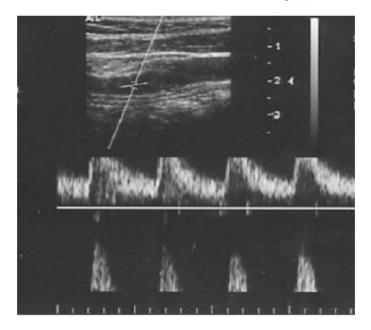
Aliasing on Doppler spectra. Due to the lower pulse repetition frequency (or low scale), the machine cannot measure the peak velocities. The top of the spectra appear as cut from the top and pasted below.
